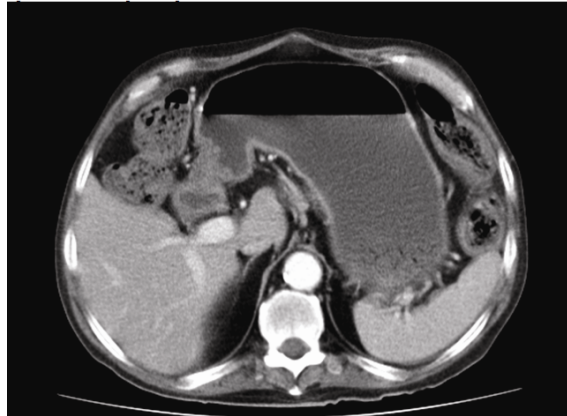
CT scan showing extreme gastric dilatation and an antral mass.
